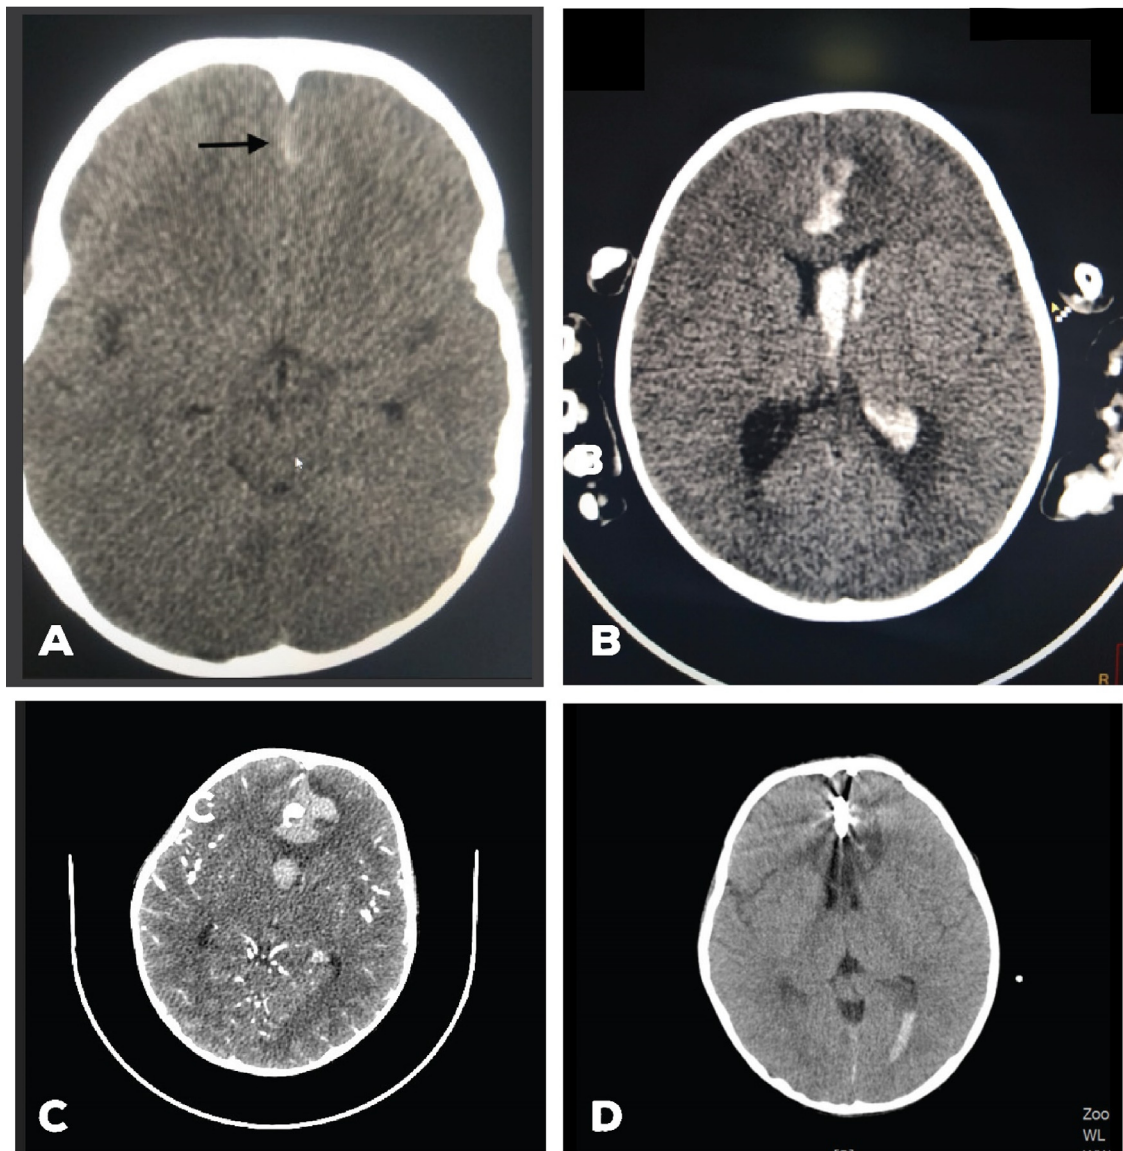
A: The first non-enhanced CT scan showed interhemisphere subdural hemorrhage.
